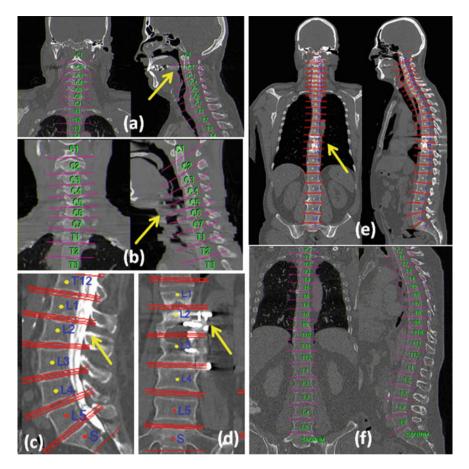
Examples of spine detection in challenging CT scans. a C-Spine scan with metal artifacts. b C-Spine scan with motion artifacts. c L-Spine scan with spinal cord disease. d L-Spine scan with metal implant. e Whole spine scan with metal artifacts. f Whole spine scan with large imaging noises
